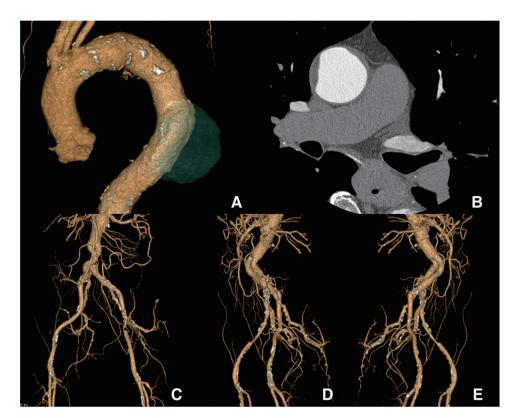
Preoperative contrast-enhanced computed tomography scan findings. A descending aortic aneurysm with a maximum diameter of 69 mm (A). Wall thrombus with a maximum thickness of 4.7 mm on the greater curvature of the ascending aorta (B). The bilateral Y-graft legs are severely angulated (C–E).
